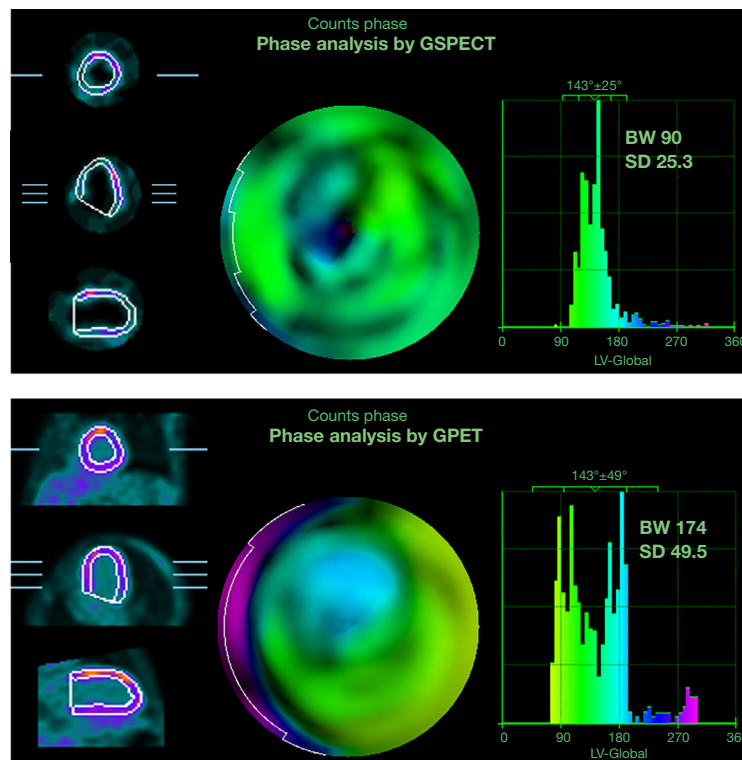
GPET overestimated the BW and SD values in an MI patient with large perfusion defects but viable myocardium. BW, histogram bandwidth; SD, standard deviation; GPET, ^{18}F -FDG gated positron emission tomography; GSPECT, $^{99\text{m}}\text{Tc}$ -MIBI gated single photon emission computed tomography; MI, myocardial infarction; LV, left ventricular.
